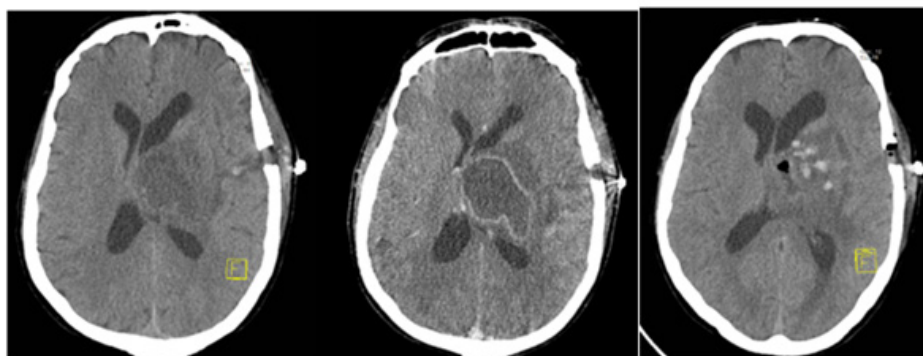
A. Postoperative CT scan, 9 days after first navigated drainage; B. contrast enhanced CT revealed abscess cavity expansion; C. CT scan after second navigated puncture and drainage of pus reveals the collapse of the abscess cavity.
